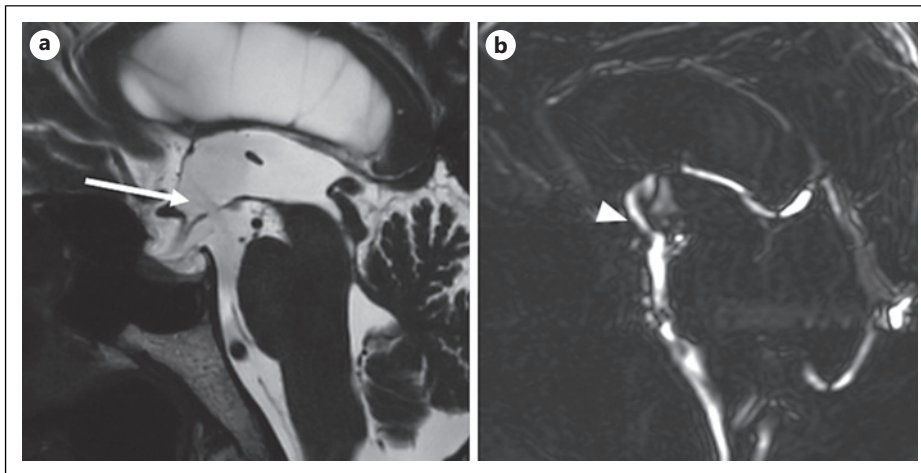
a Postoperative MRI confirmed the fenestrated floor of the third ventricle (white arrow). b Phase-contrast cine MRI detects CSF flow in the same area (white arrowhead).
